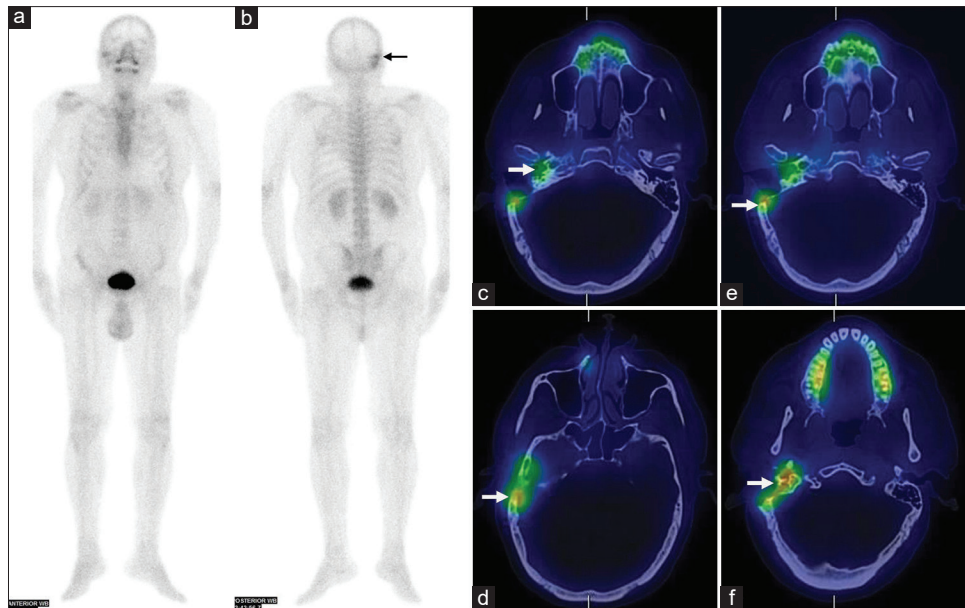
^{99m}Tc -MDP bone scan anterior and posterior image showing increase uptake in the right temporal bone (a-b). SPECT/CT images showed increased tracer uptake in the right squamous temporal bone, right mastoid air cells, and right petrous temporal bone (c-f)
